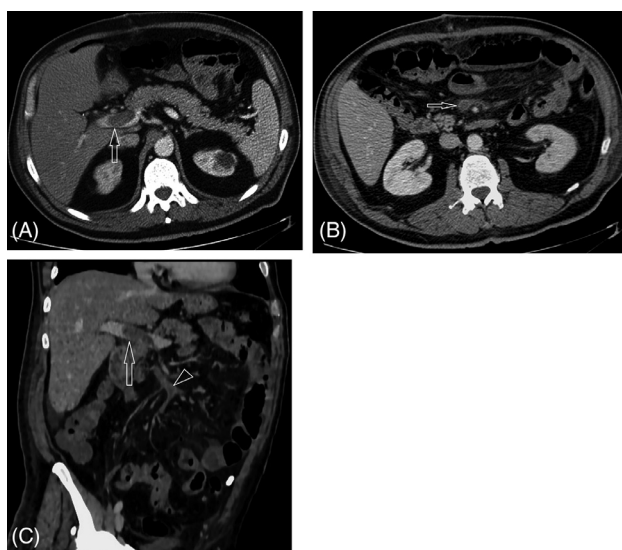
Contrast-enhanced computed tomography (CT) on day 5 postoperative. (A) Extension of the thrombosis to the portal vein with a filling defect during venous phase contrast-enhanced CT (white arrow). (B) Presence of superior mesenteric vein thrombosis with a filling defect during venous phase contrast-enhanced CT (white arrow). (C) Oblique reconstructed image showing thrombosis with a filling defect in the superior mesenteric vein (white arrow head) and its extension to the portal vein (white arrow).
